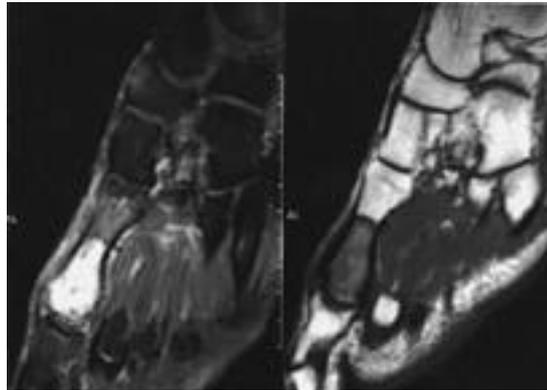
MRI shows homogeneous low signal intensity in T1WI(Right) and heterogeneous high signal intensity in T2WI(Left).
